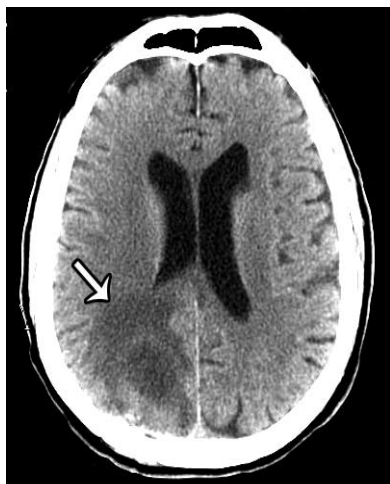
The CT scan of brain 12 days after drainage.
